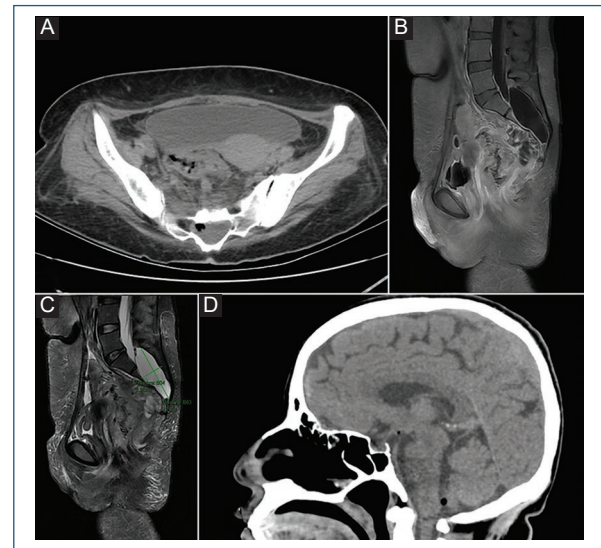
A: non-contrast CT at the sacral level showing disruption of the anterior wall and S5 vertebral body, with a heterogeneous 40-cc collection exerting mass effect on the spinal canal and containing air bubbles. B: contrast-enhanced CT showing collections with peripheral contrast enhancement. C: STIR MRI sequence showing an intraspinal collection with CSF-like characteristics. D: pneumocephalus in the posterior fossa and supratentorial region.
